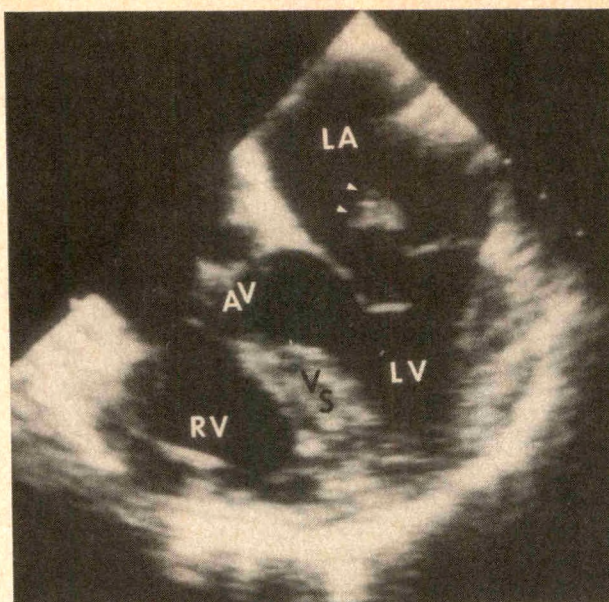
Systolic still frame of transesophageal 4-chamber view, demonstrating papillary muscle rupture. Ruptured head of the papillary muscle (arrowheads), attached to the posterior mitral leaflet, flails into the left atrium (LA). The mitral valve coaptation is grossly inadequate, allowing massive mitral regurgitation. AV = aortic valve; LV = left ventricle; RV = right ventricle; VS = ventricular septum.
